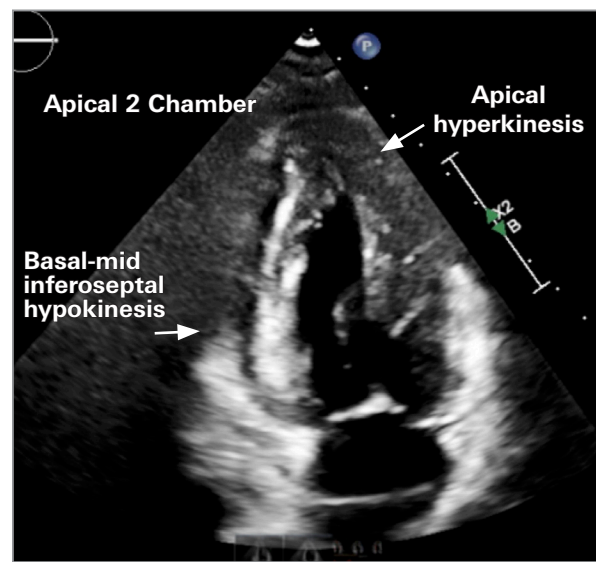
The apical 2-chamber echocardiogram view shows basal-mid inferior hypokinesis and apical hyperkinesis.
